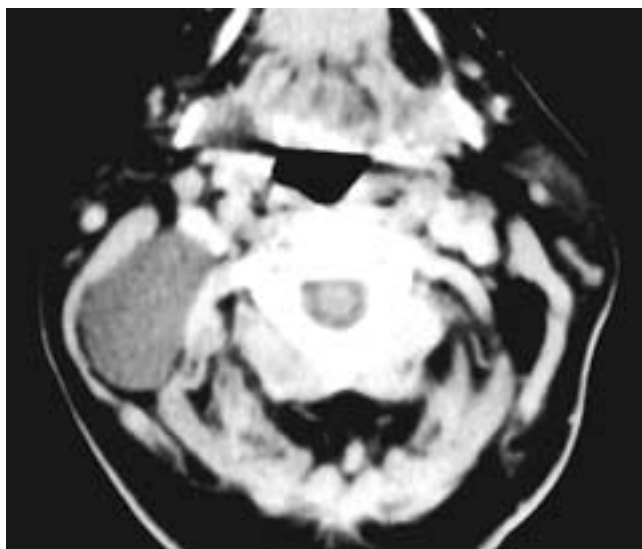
Axial contrast-enhanced CT scan shows a cystic mass in the right neck deep to the sternocleidomastoid muscle and superficial to the muscles that comprise the floor of the posterior triangle of the neck. The mass fills this space, which has been variously referred to as the spinal accessory nodal space, the posterior cervical nodal space, the posterior triangle space, and the posterior cervical space. This lesion was a solitary lymphangioma in an adult but could just as easily have been a node in a patient with lymphoma.
